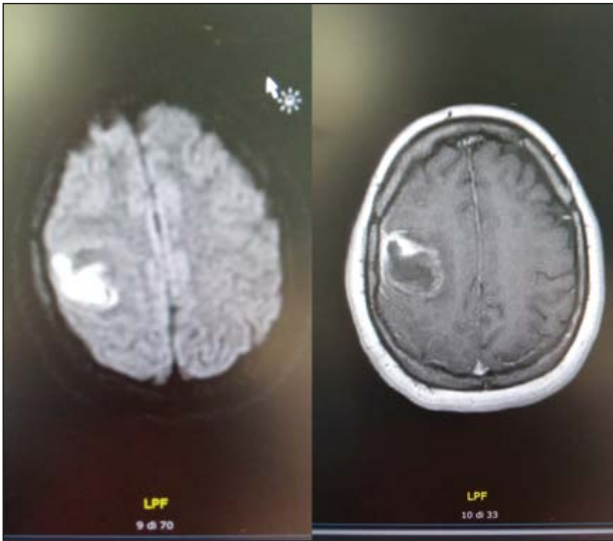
Hypodense lesion left frontal lobe associated with voluminous perilesional edema compatible with abscess by MRI.
